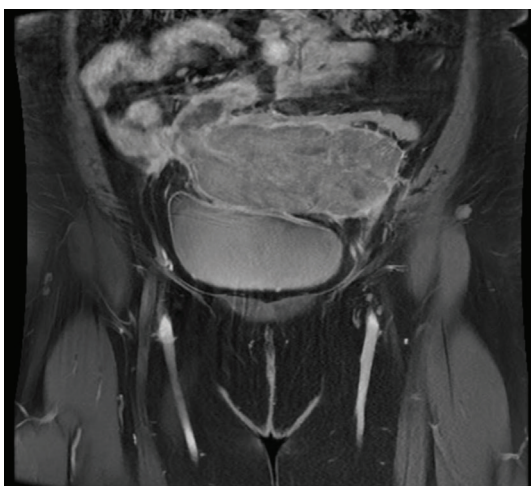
Coronal pelvic magnetic resonance image showing the same heterogeneous pelvic mass measuring approximately 12.4 × 6.8 × 6.1 cm (craniocaudal × transverse × anteroposterior dimensions). The lesion demonstrates heterogeneous enhancement and causes anterior displacement of the urinary bladder without direct infiltration. No pelvic lymphadenopathy or ascites is identified.
